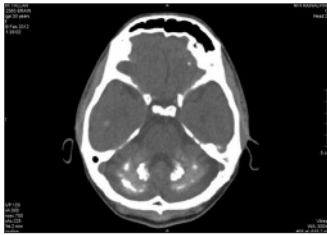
Axial CT slice showing calcification of dentate nuclei and cerebellar white matter.
